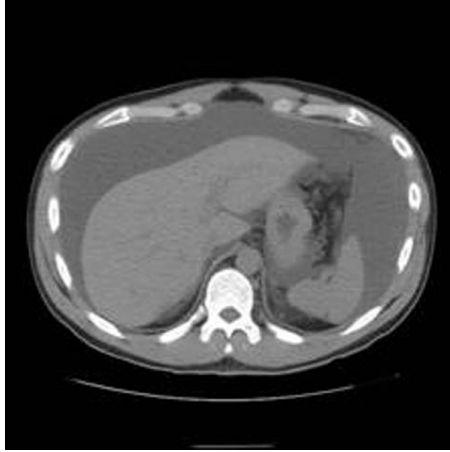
Abdominal CT scan revealing large amount of ascites
